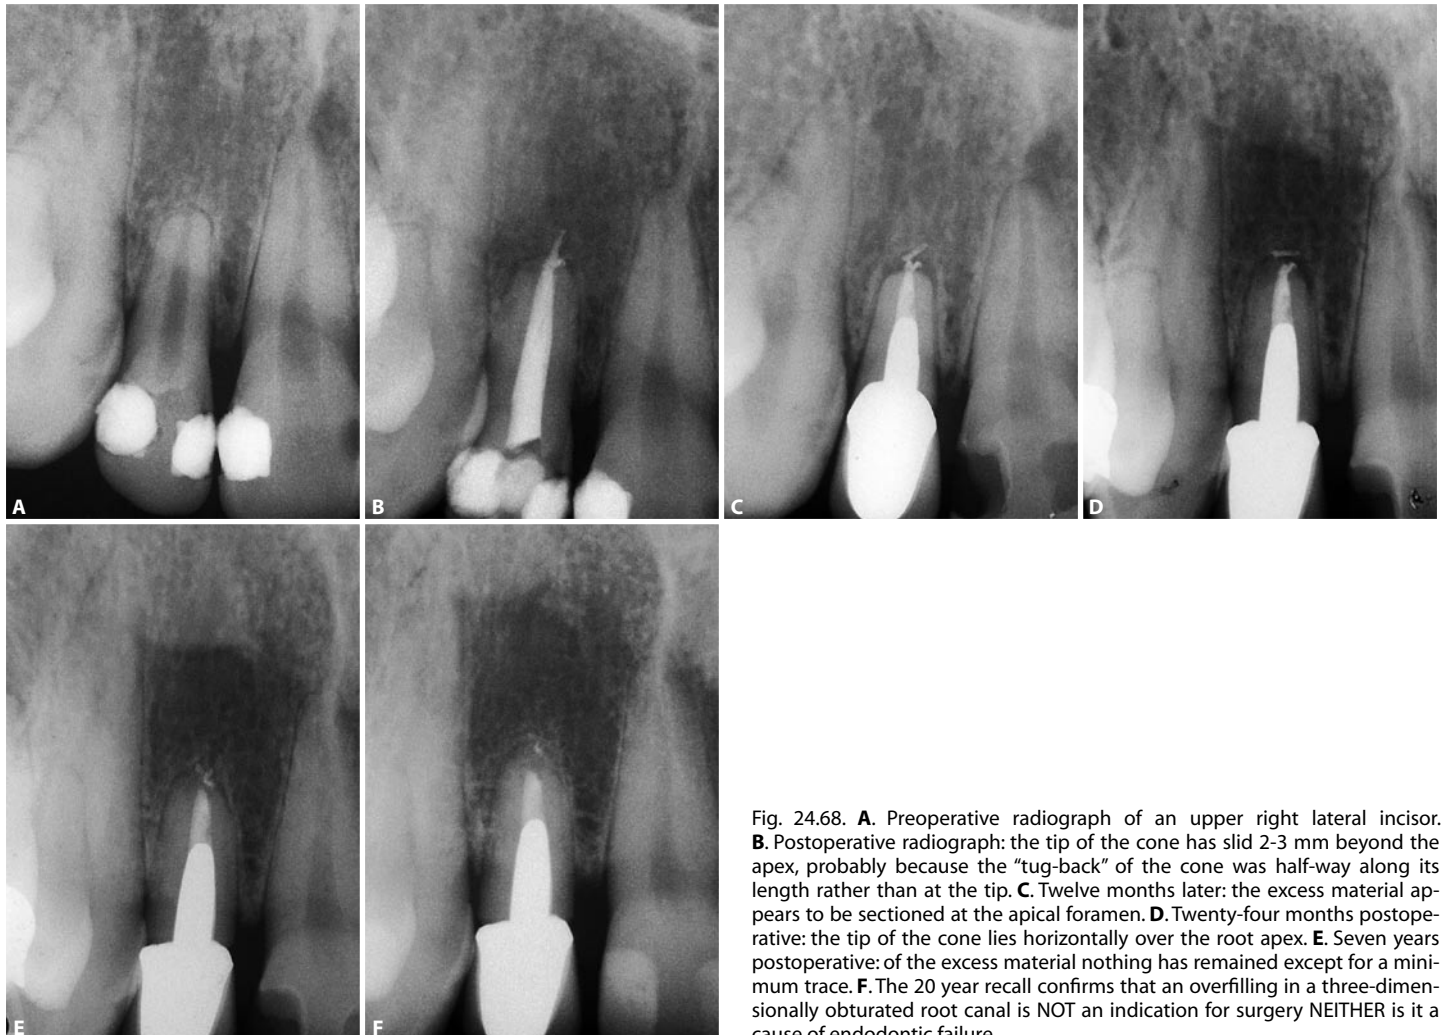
A. Preoperative radiograph of an upper right lateral incisor. B. Postoperative radiograph: the tip of the cone has slid 2-3 mm beyond the apex, probably because the "tug-back" of the cone was half-way along its length rather than at the tip. C. Twelve months later: the excess material appears to be sectioned at the apical foramen. D. Twenty-four months postoperative: the tip of the cone lies horizontally over the root apex. E. Seven years postoperative: of the excess material nothing has remained except for a minimum trace. F. The 20 year recall confirms that an overfilling in a three-dimensionally obturated root canal is NOT an indication for surgery NEITHER is it a cause of endodontic failure.
